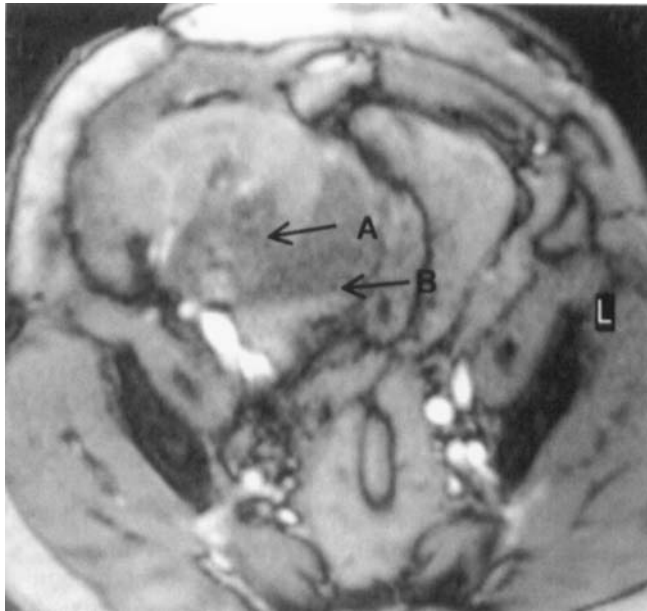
T1-weighted MRI sequence: *arrow A* indicates the infarcted lower pole, whereas *arrow B* shows the perirenal collection
